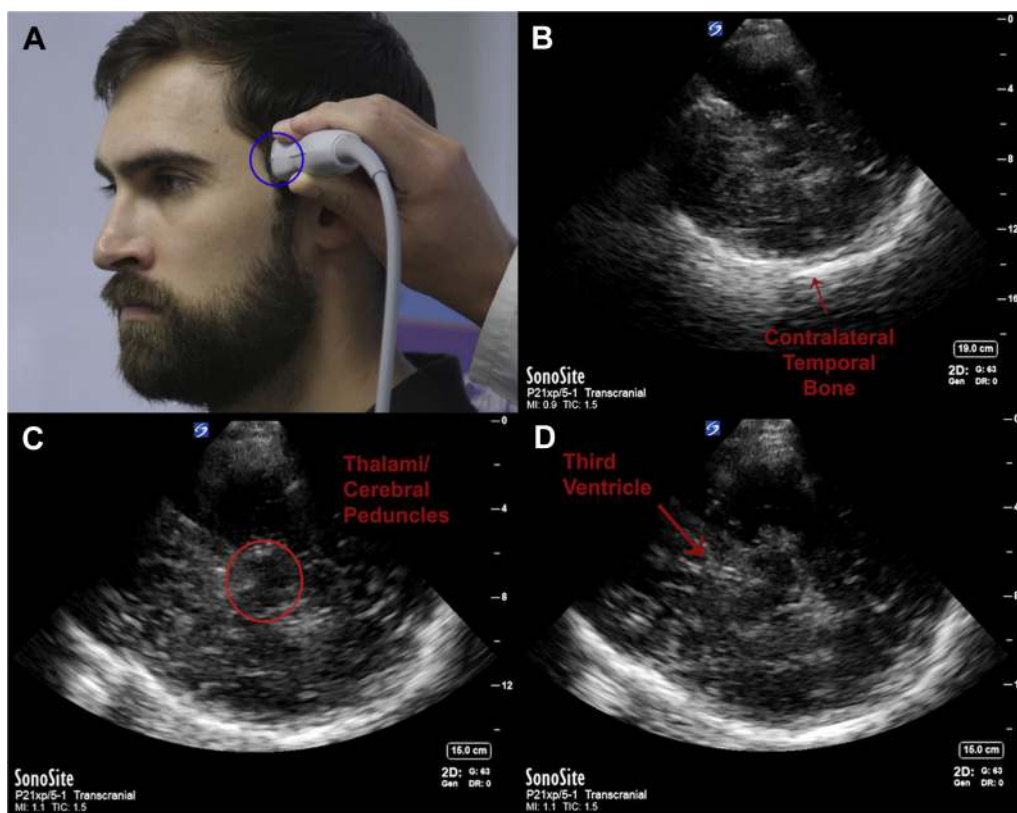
A-D, Basics of transcranial Doppler anatomy and image acquisition. A, The initial transducer position for the transtemporal window. B, Locating the contralateral temporal bone. C, Locating the midbrain. D, Locating the third ventricle.
